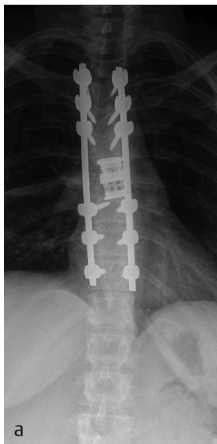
Postoperative anteroposterior (a) and lateral (b) radiographs of posterior spinal fusion instrumentation from T4 to T11. Expandable cage was placed during first-stage procedure after corpectomy of T7 and T8 vertebral bodies; posterior instrumentation was placed during second-stage procedure 2 days later. Regional kyphosis improved from 57 degrees of thoracic kyphosis preoperatively to 32 degrees postoperatively.
